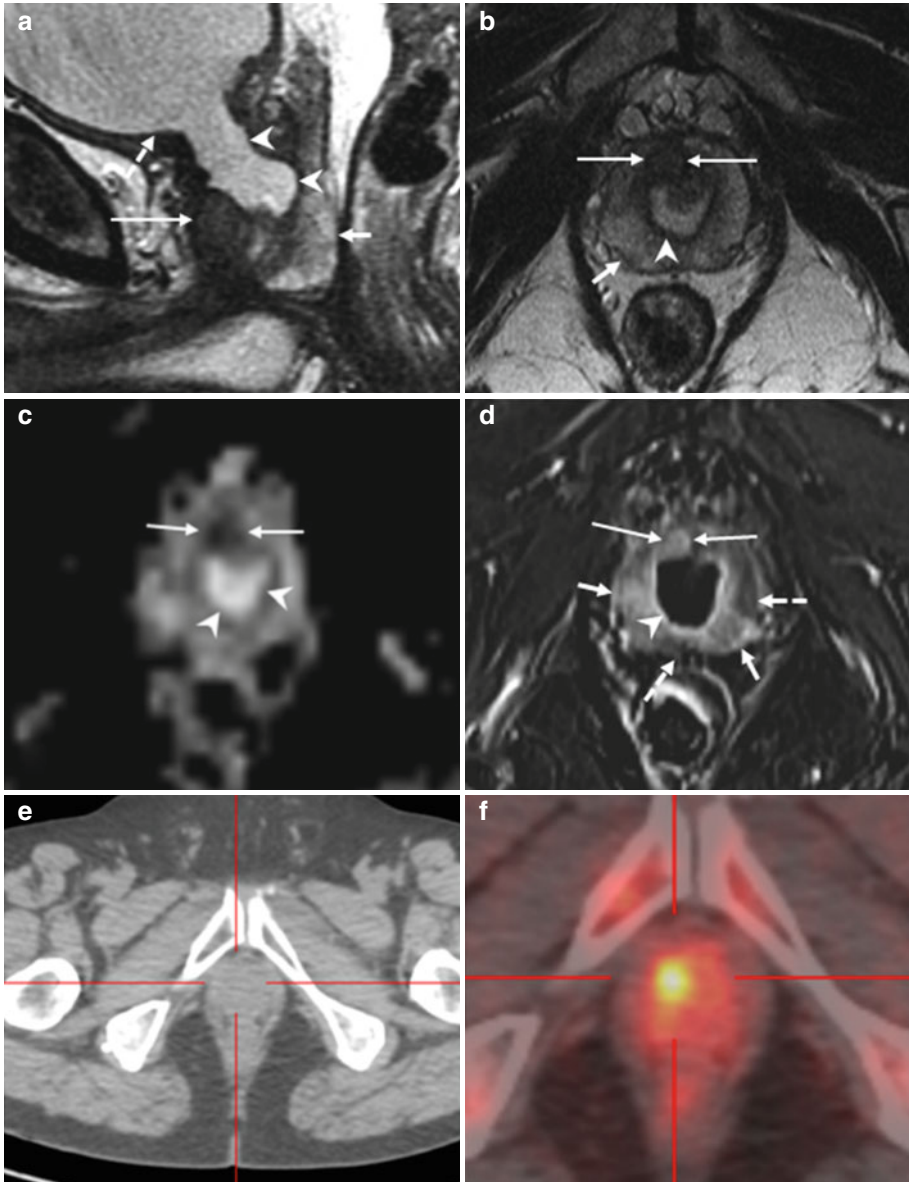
(a–f) 68 years old, undergone TURP 3 years ago for BPH (PSA: 4–5 ng/ml; free-to-total ratio: 18 %); in the next years, the PSA values increased and free-to-total PSA ratio dropped (last values: respectively, 11–2 ng/ml; 7 %); these values are suspected for neoplastic lesion. The patient underwent prostate biopsy that revealed a prostatic cancer (Gleason 3+3). On sagittal T2-weighted sequence (TR: 3600; TE: 114) (a), the prostate (short arrow) appears regularly hyperintense, with the exception of a hypointense lesion anteriorly (long arrow); appreciable in this plane is a large bladder neck (arrowheads), consequence of a previous resection of the median lobe, just below the bladder (dashed arrow). Axial T2-weighted (TR: 3600; TE: 116) sequence (b) shows the hypointense lesion (long arrow), anteriorly, just to the right of the midline, while the remaining prostate is hyperintense (short arrow); within the prostate, the bladder neck is
